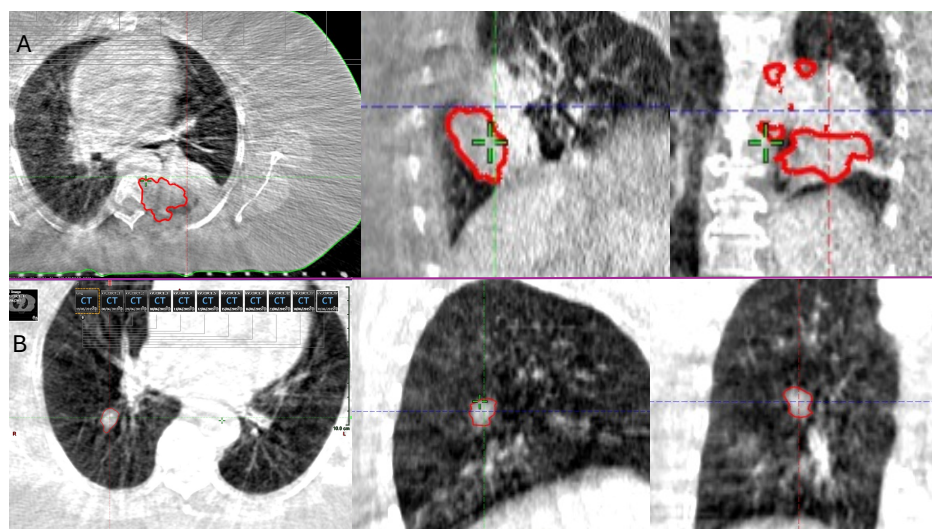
Examples of Auto Contours derived by Smart Segmentation on CBCT datasets
